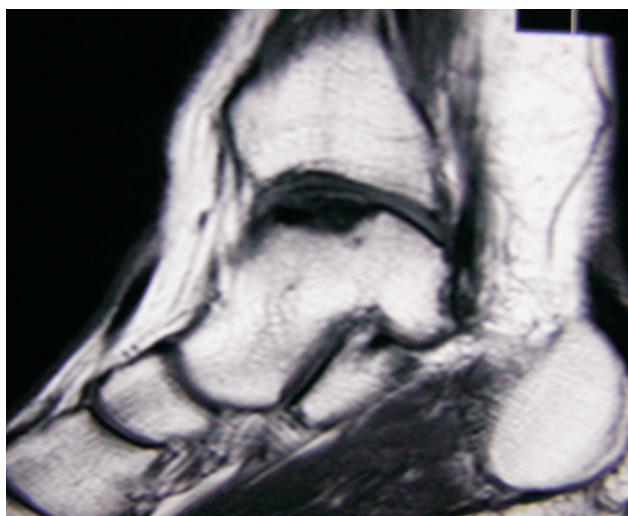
Preoperative magnetic resonance image of the talar dome lesion.
